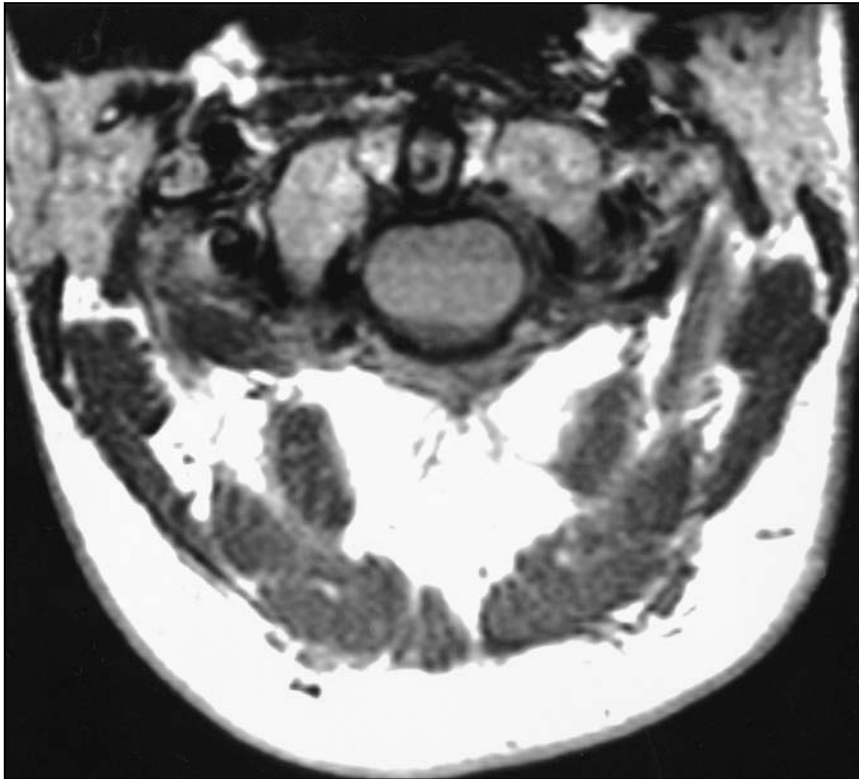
T1-weighted axial magnetic resonance imaging scan, showing the neurenteric cyst.
